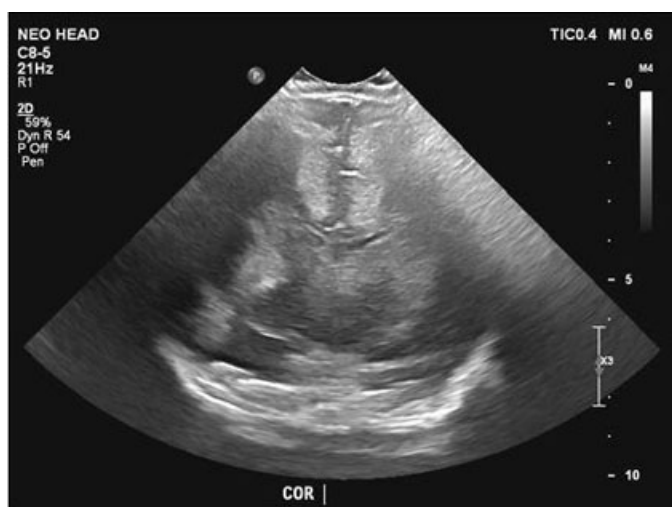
Cranial ultrasound. Suboptimal evaluation due to significant amount of artifact. Grossly abnormal echogenic parenchyma throughout both cerebral hemispheres, particularly involving the subcortical and deep white matter of the frontal lobes.
